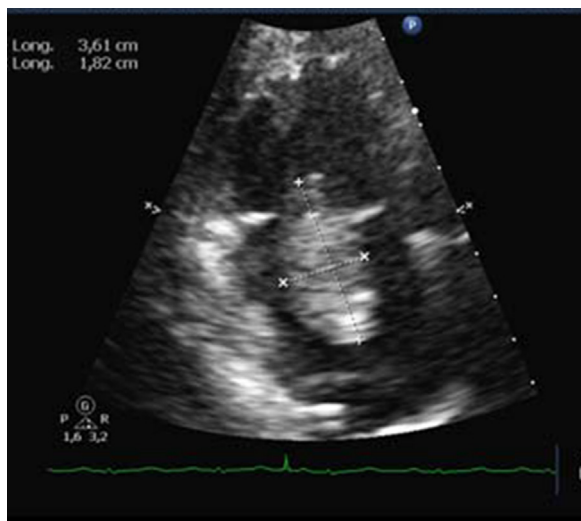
Transthoracic echocardiography of right heart structures showing tricuspid valve with a large vegetation (36 × 18 mm) suggestive fungal endocarditis.
